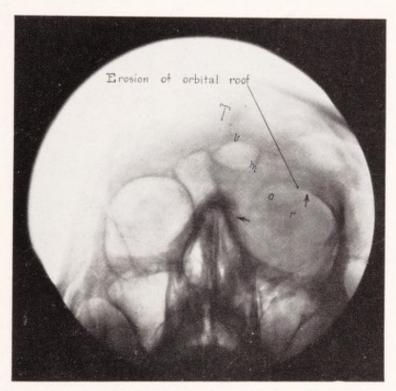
Case 2. Retouched X-ray showing destruction of roof of orbit and anterior wall of skull by tumor.
